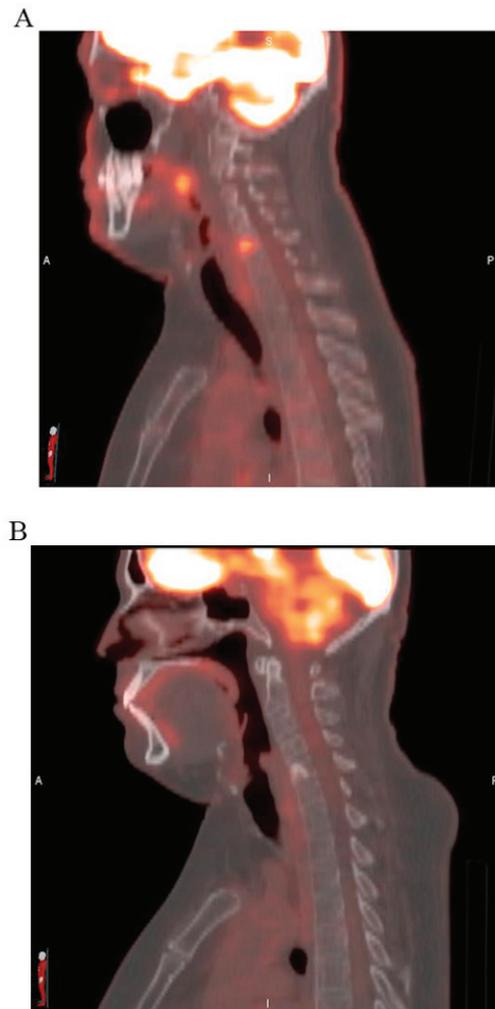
Baseline PET CT scans. (A) Sagittal view demonstrating metastatic disease to the 5th vertebral body of the cervical spine. (B) Post treatment PET CT demonstrating resolution of FDG activity involving the 5th vertebral body of the cervical spine with overlying sclerosis.
